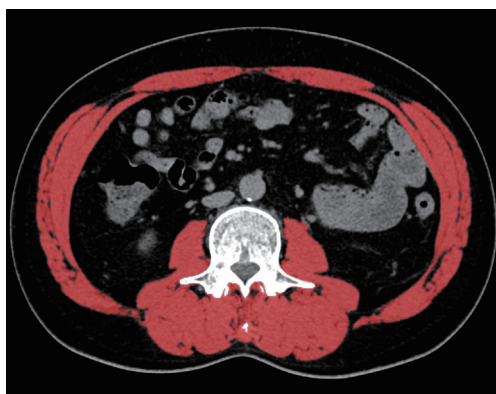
Cross-sectional CT images at the lumbar level. Skeletal muscles (red shadows) were identified and measured from -29 to $+150$ HU. CT, computed tomography.
